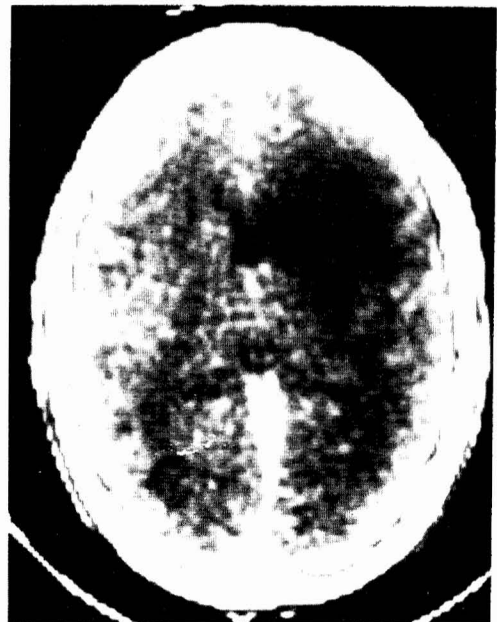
Computed tomographic scan reveals an area of decreased density in the right frontotemporoparietal region.
